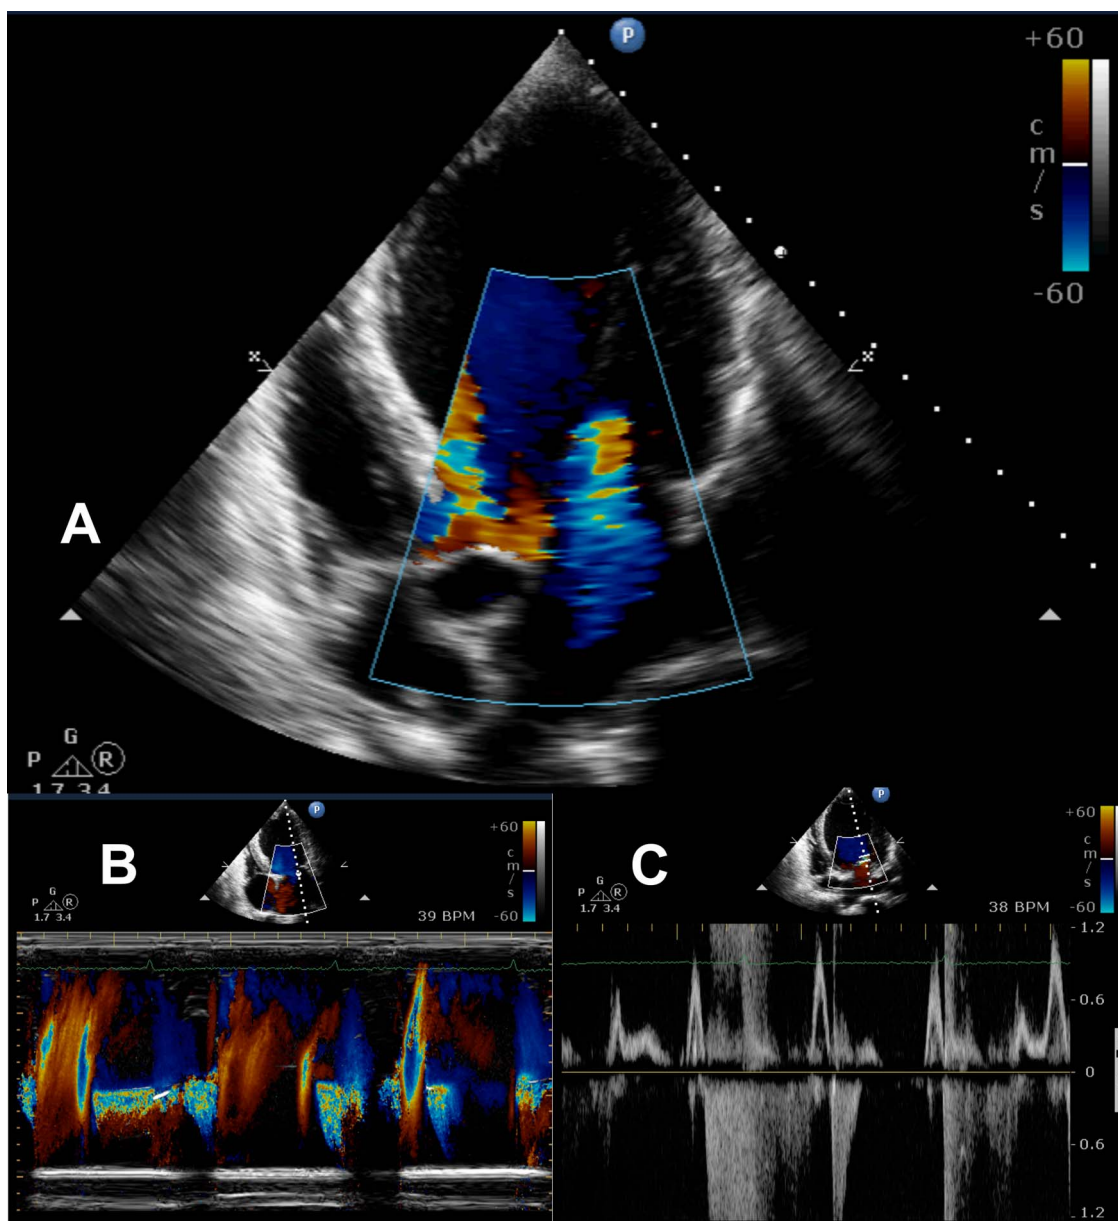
(A) Transthoracic echocardiogram. Colour flow imaging shows aortic and mitral regurgitation in the same frame. (B) Colour M mode across the mitral valve showing systolic and diastolic mitral regurgitation. (C) Pulsed wave Doppler at the mitral valve showing both systolic and diastolic mitral regurgitation.
